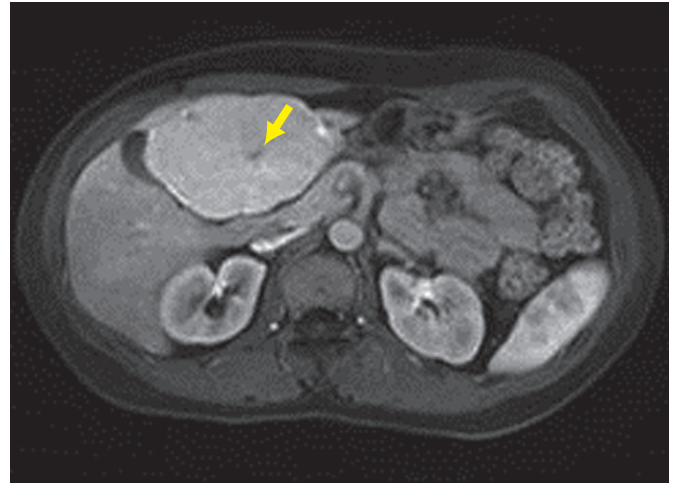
Enhancing lesion on arterial phase MRI. Central scar (arrow) is non-enhancing on this phase.
